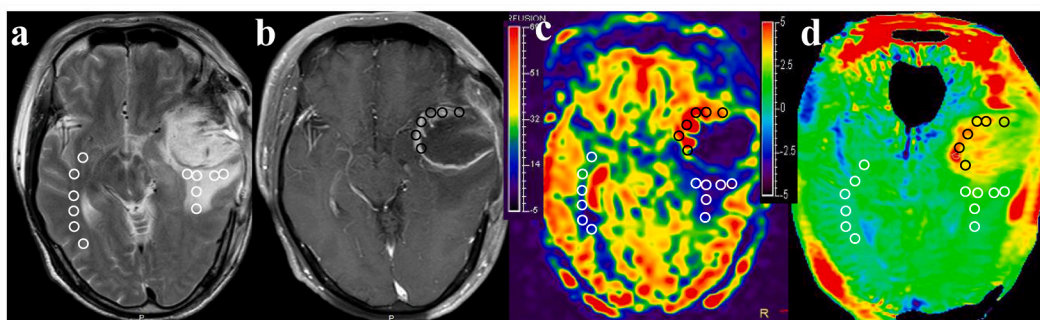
The findings were observed in a 58-year-old patient with typical TR. The multiparametric MR images, including T2WI (a), Gd-enhanced T1WI (b), CBF (c), and APTw (d) maps, demonstrate a lesion in the left temporal lobe with significantly heterogeneous enhancement. Importantly, this enhancing lesion is characterized by remarkably high and red signal intensities on both CBF and APTw maps. The EA, PHA, and CNWMA were divided into six equal-sized ROIs. These ROIs were then overlaid onto the CBF and APTw maps to calculate the mean CBF and APTw values for each region. The average CBF values in TR lesion of the left temporal lobe were as follows: 58.64 mL/100 g/min for EA, 27.93 mL/100 g/min for PHA, and 24.75 mL/100 g/min for CNWMA. The average APTw values in TR lesion were as follows: 4.08 % for EA, 2.63 % for PHA, and 1.64 % for CNWMA.
